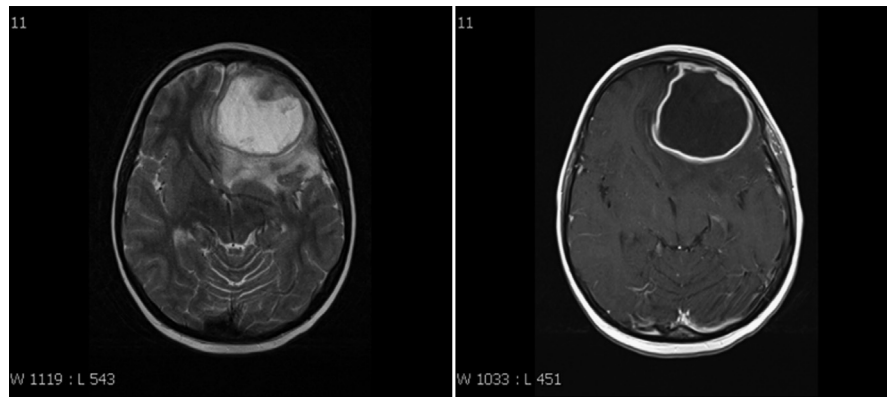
Patient2: axial T2 (left) weighted image and T2 (right) contrast enhanced MRI-cerebrum show a large lesion with surrounding edema and rim enhancement.
